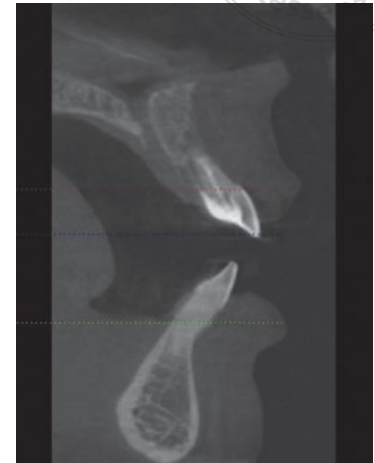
CBCT showing a periapical lesion at tooth 11.
